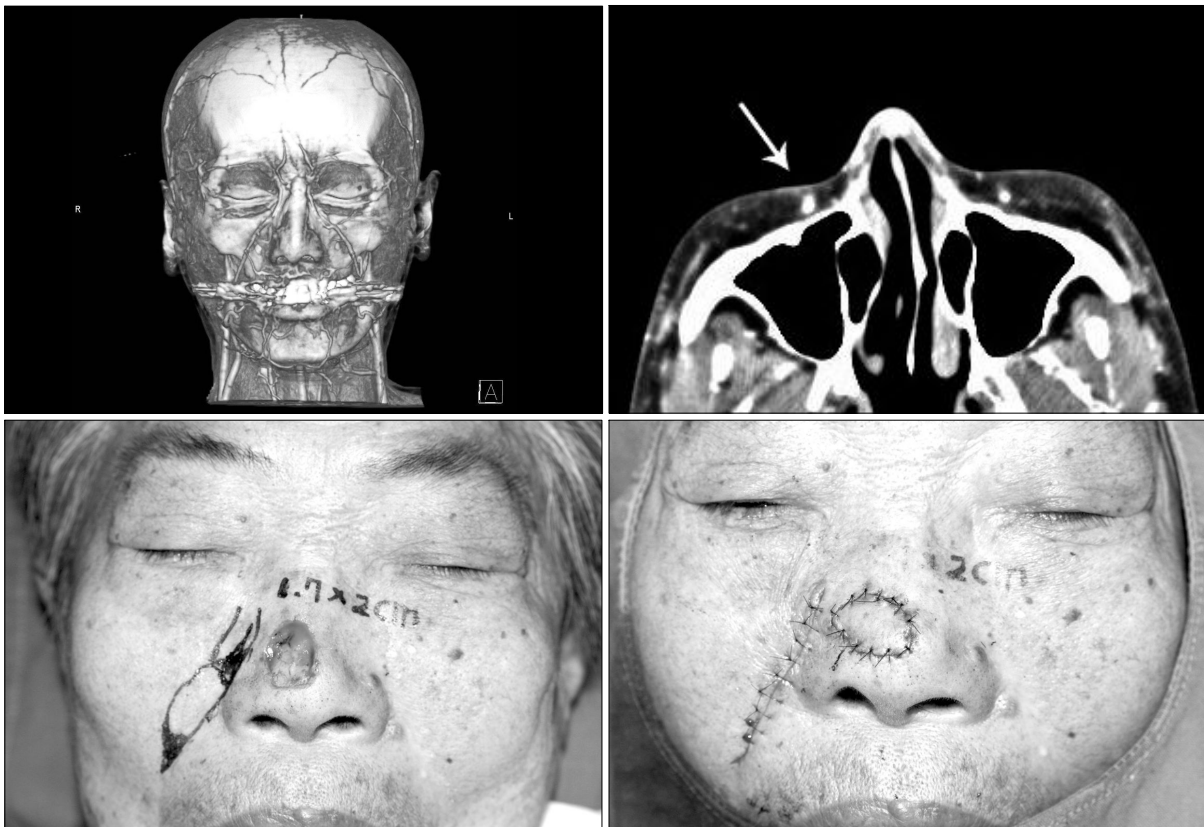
Case 1. A 65-year-old male with nasal tip defect caused by a basal cell carcinoma resection. (Above, left) Preoperative Angio-CT shows anatomic information of both facial arteries. Rt. angular artery is closer to the nasolabial fold. (Above, right) The diameter of the right angular artery is larger than the left side. The arrow indicates the right angular artery. (Below, left) Preoperative photo. (Below, right) The nasal defect was reconstructed successfully using a right retroangular flap.
